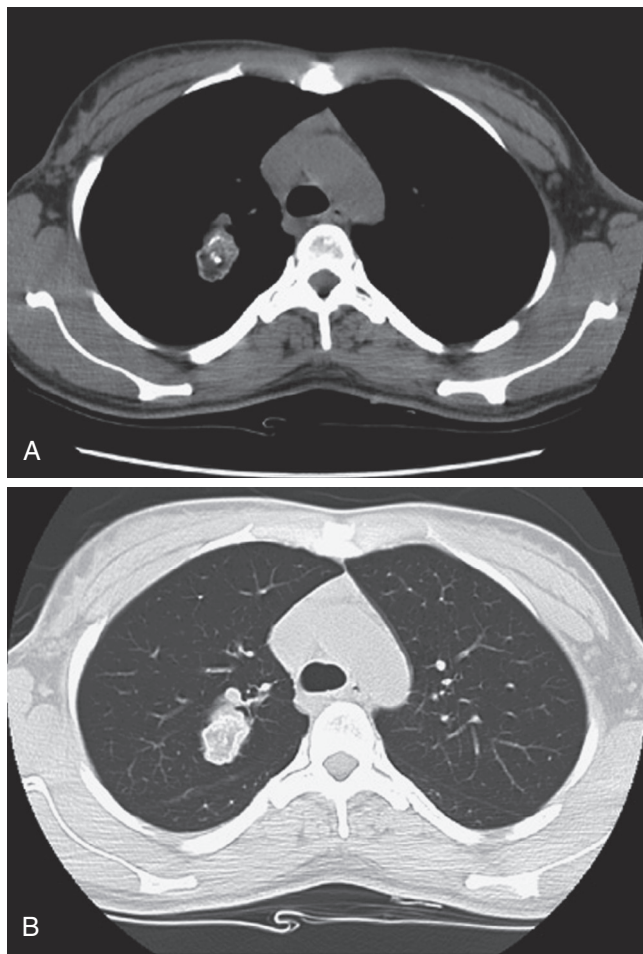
■ A, Right lung hamartoma. The lesion was resected, and a benign process was confirmed. Lesions are most often located in the lower lung fields and are well circumscribed. B, The majority are less than 4 cm in diameter, and calcifications can be appreciated on radiographs in 10% to 30% of cases.
